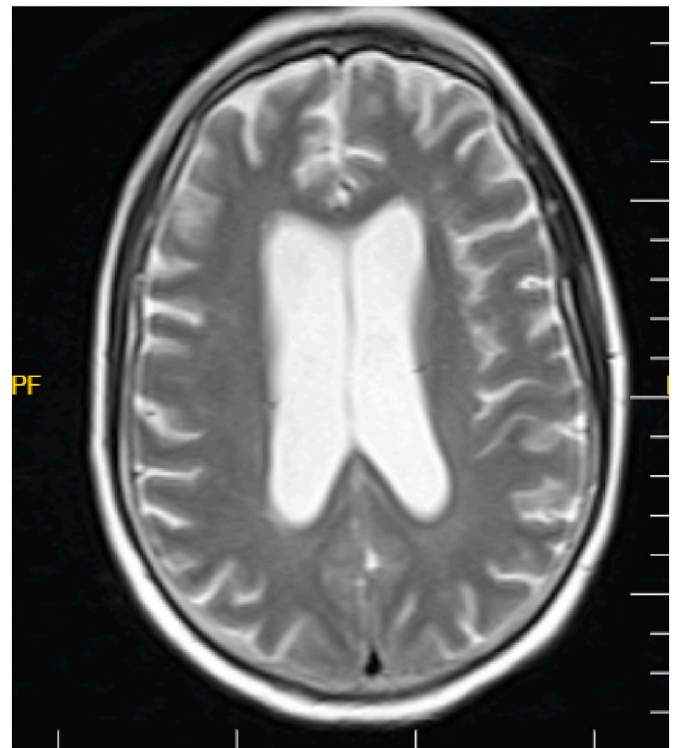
Brain MRI T2 sequence.
